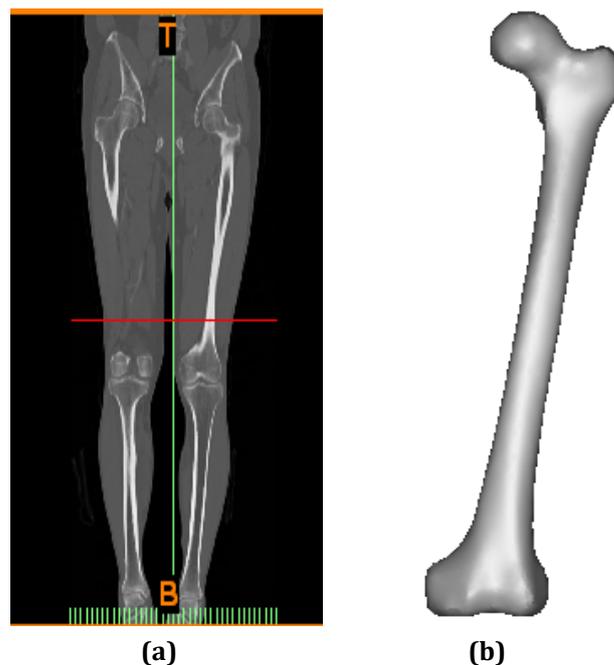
Three-dimensional bone (a) CT Data set; (b) 3D femoral bone
